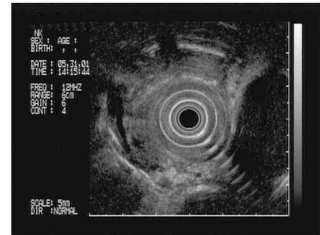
Endoscopic ultrasound for esophageal cancer staging reveals a stage T4 esophageal cancer. From the 7 o'clock to 9 o'clock positions there is invasion of the azygos vein.
